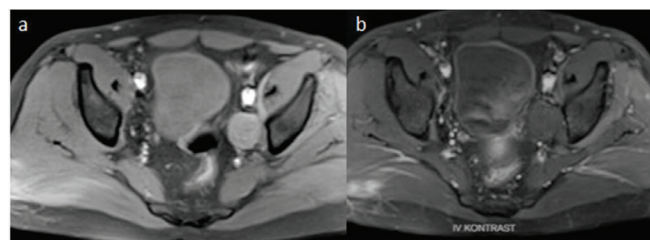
Aksial T1W fat saturated non-contrast (a) ve contrast (b) abdominal MR images show non-enhancing mass.
